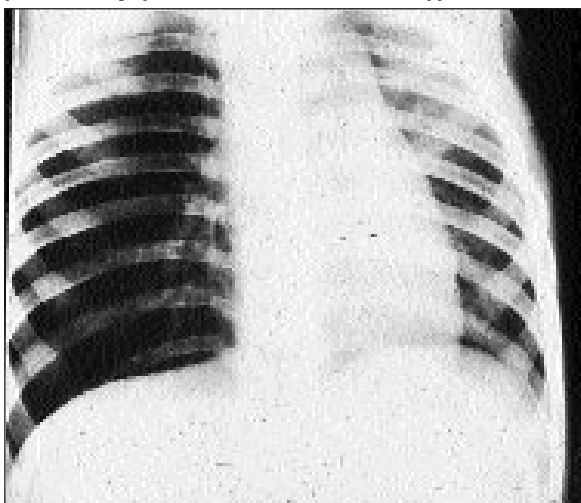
Foreign body in the right bronchus. Chest X-ray shows hyperinflation of the right lung as a result of partial obstruction. A piece of orange peel was recovered at bronchoscopy.
